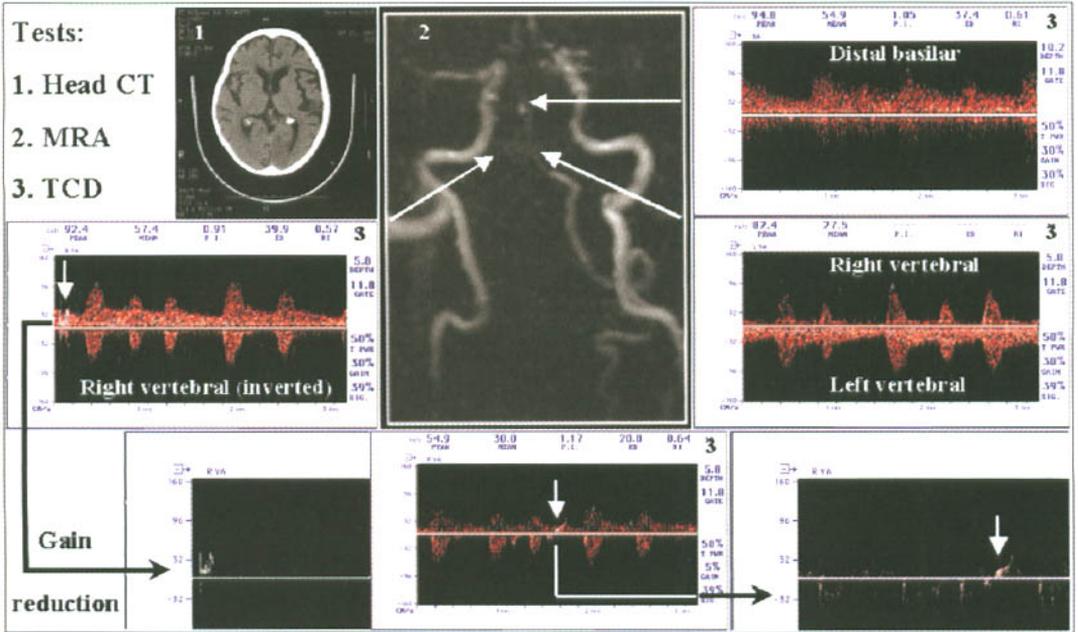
Computed tomography, magnetic resonance imaging and transcranial Doppler findings in an
